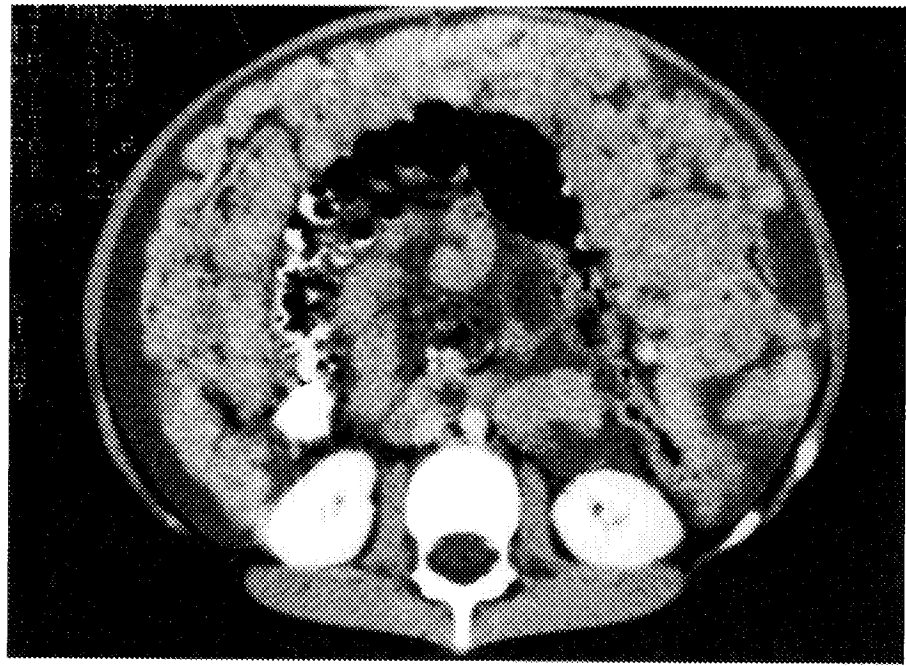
CT scan of abdomen at diagnosis. There is extensive ascites and gross induration of the greater omentum, which is infiltrated by tumor to form a thick omental cake.
